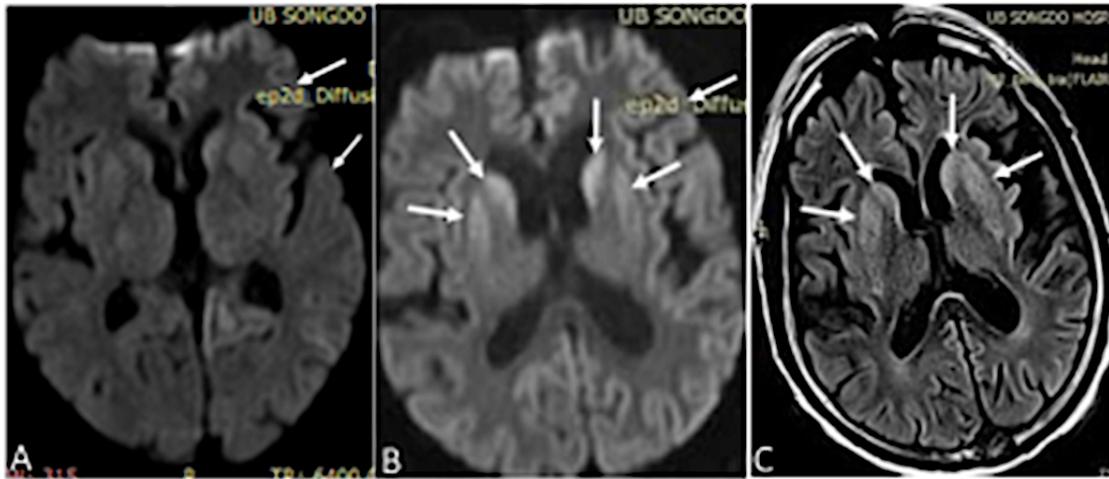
Patient H.O. 65 years old, male, diagnosis: sCJD; In the MRI-DWI axial imaging of the brain, focal changes (more on the left) with increased signal intensity (more on the left) were detected in (A) parietal, frontal, temporal cortex, cingulate gyrus, (B, C) caudate and putamen.
